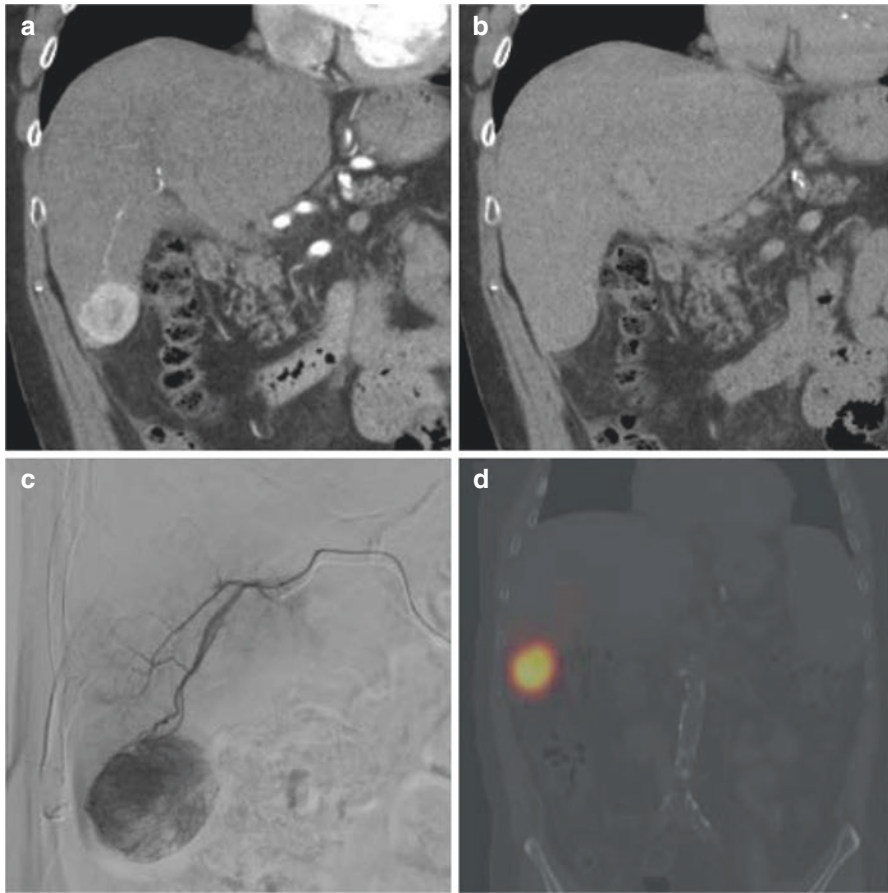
A 73-year-old man with alcoholic cirrhosis and segment VI hepatocellular carcinoma treated with Y90 radiation segmentectomy. (a) Arterial phase and (b) delayed phase coronal images from a four-phase CT demonstrate a 3.6 cm segment VI LiRads-5 lesion with arterial enhancement and delayed washout and pseudocapsule. (c) Segmental angiogram just prior to delivery of Y90 glass beads. (d) SPECT-CT from technetium-99m macroaggregated albumin (99mTc MAA) from planning study demonstrating preferential delivery of arterially administered 99mTc MAA to tumor tissue relative to adjacent liver
